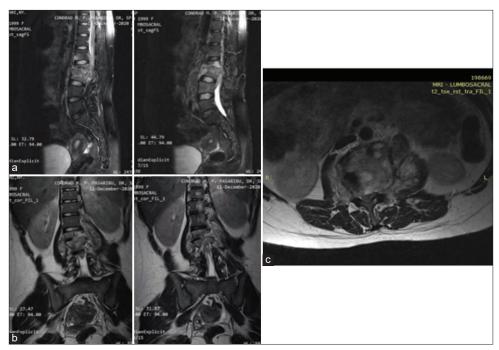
Thoracolumbar MRI in a 21-year-old female with spinal TB. Noncontrast MRI in the lumbosacral region showed hypointense (in T1-weighted images) and hyperintense (in T2-weighted images) mass in the paravertebrae at the L1-L4 level. (a) Sagital view; (b) Coronal view; (c) Axial view.
